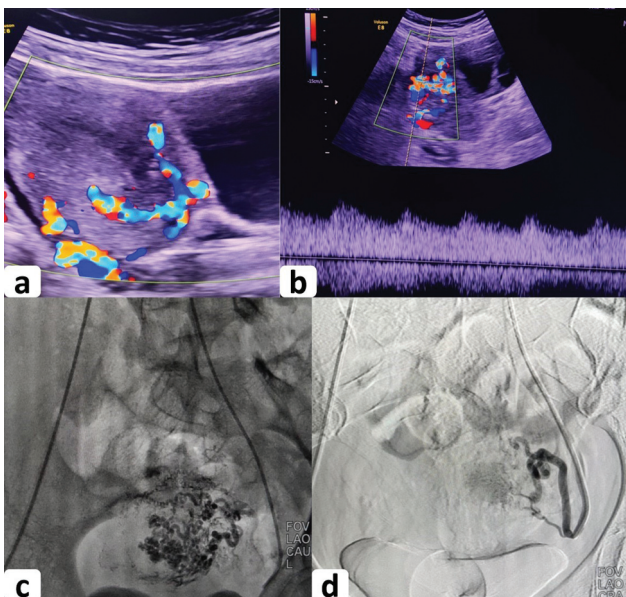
Ultrasound and angiographic images of left uterine artery embolization performed for uterine non-arteriovenous malformation (AVM) in 24-year-female patient. (a) Color Doppler ultrasound image showing dilated myometrial vessels reaching up to the endometrium; (b) spectral Doppler showing low resistance high-velocity waveform; these findings correspond to uterine AVM; (c) contralateral uterine angiogram showing tortuous and hypertrophied vessels, without early draining vein; (d) postembolization with polyvinyl alcohol particles, significant reduction of the abnormal vessels noted with preserved proximal main artery.
